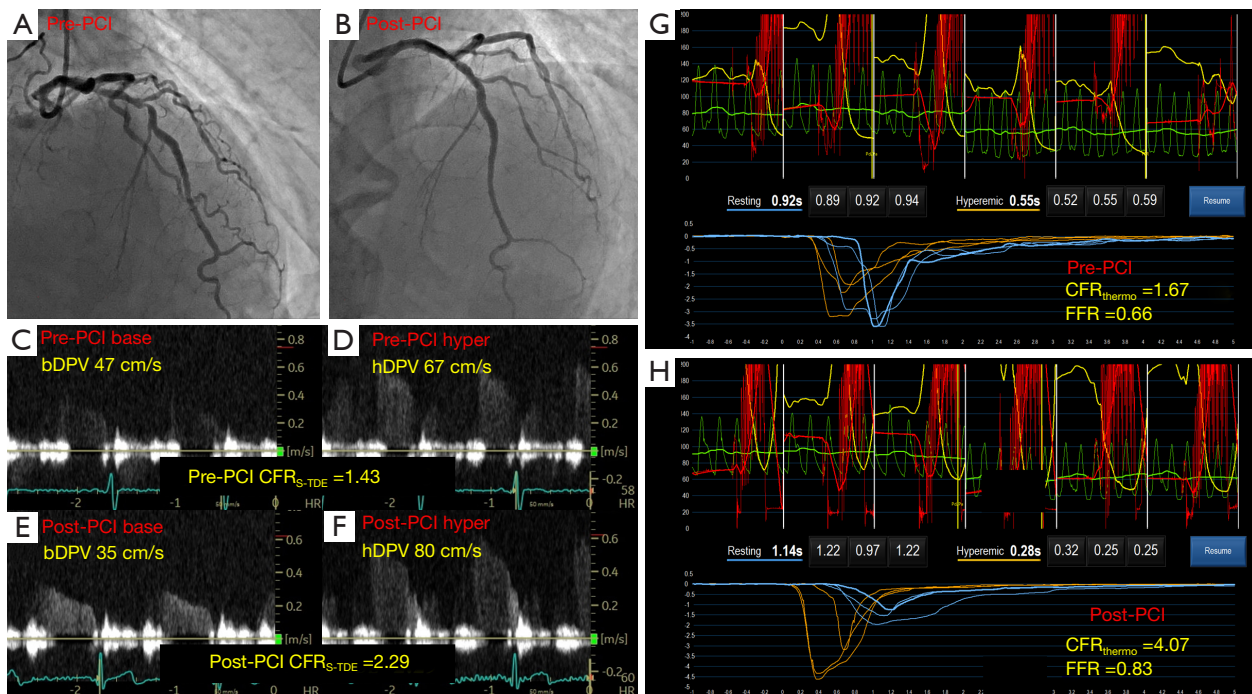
Representative images of coronary flow velocity measurements. A representative case of an LAD lesion that underwent S-TDE and thermodilution examinations before and after successful PCI. (A) Pre-PCI angiography. (B) Post-PCI angiography. (C) Pre-PCI bDPV. (D) pre-PCI hDPV. (E) Post-PCI bDPV. (F) Post-PCI hDPV. (G) Pre-PCI CFR_{thermo} . (H) Post-PCI CFR_{thermo} . LAD, left anterior descending artery; S-TDE, stress transthoracic Doppler echocardiography; PCI, percutaneous coronary intervention; bDPV, base diastolic peak velocity; hDPV, hyper diastolic peak velocity; CFR_{thermo} , thermodilution-derived coronary flow reserve; CFR_{S-TDE} , stress transthoracic Doppler echocardiography-derived coronary flow velocity reserve; FFR, functional flow reserve.
